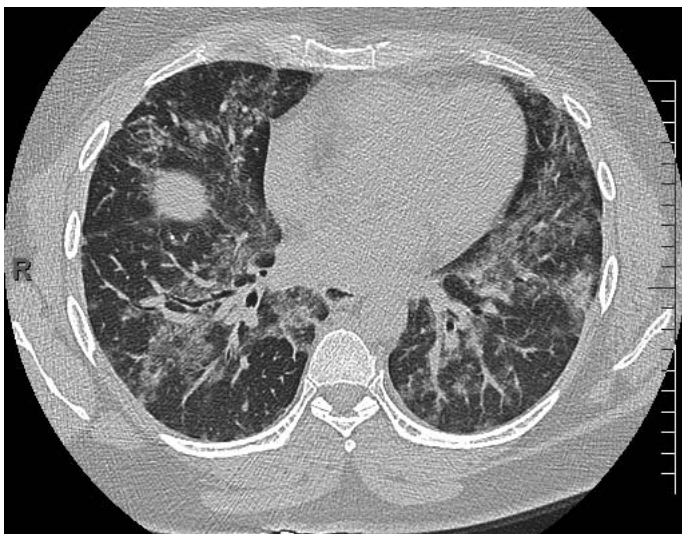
A representative computed tomography scan of the chest from a patient with undifferentiated connective tissue disease.
